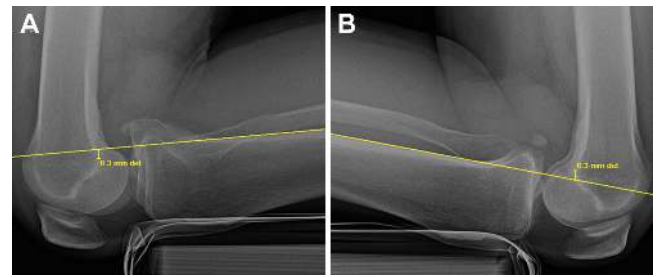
Posterior kneeling stress radiographs. (A) Lateral radiograph of the injured right knee reveals 6.3 mm of posterior tibial translation, as opposed to the (B) lateral radiograph of the uninjured left knee with 6.3 mm of anterior tibial translation, indicating a complete posterior cruciate ligament tear with a side-to-side difference of 12.6 mm of posterior tibial translation.
